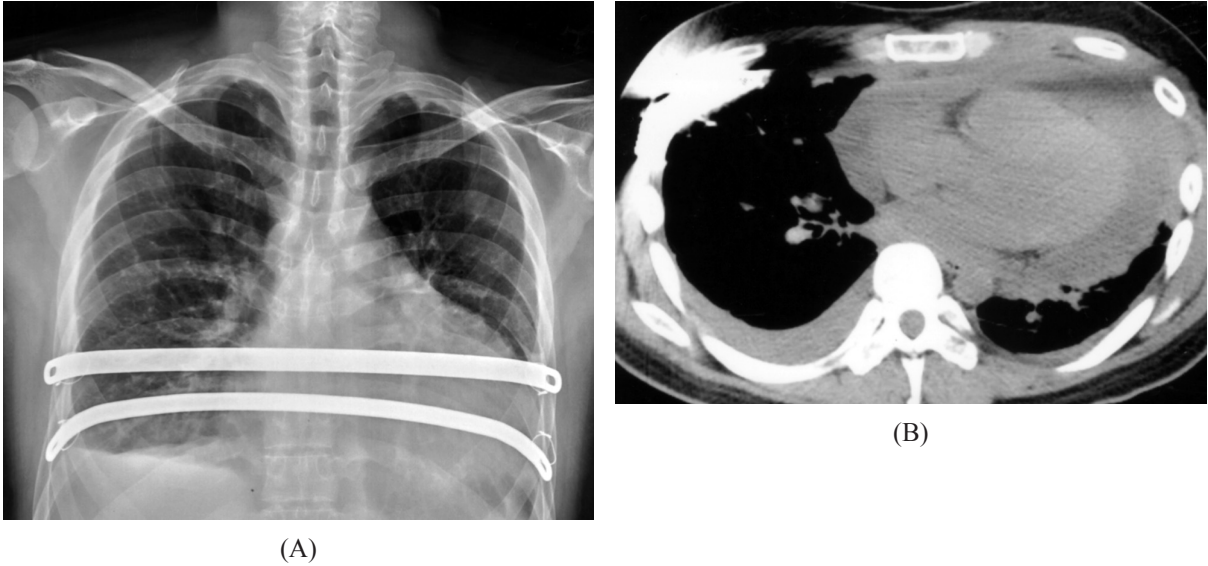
(A) Chest radiograph 4 weeks after the Nuss procedure showing increased cardiac size and displacement of the lower pectus bar. (B) Chest CT revealing fluid accumulation in the pericardial cavity.
